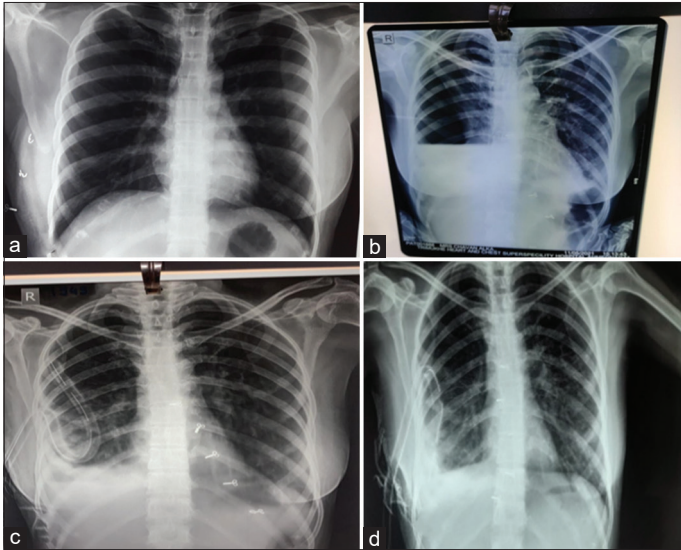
X-ray (a) 1 week before admission; (b) day 15; (c) day 16–25; (d) day 26–40 of admission
